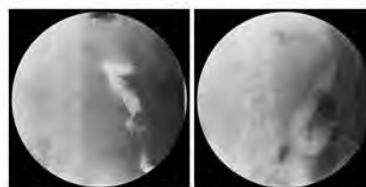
X-ray examination of the passage of the gastrointestinal tract in the patient on the first day.
